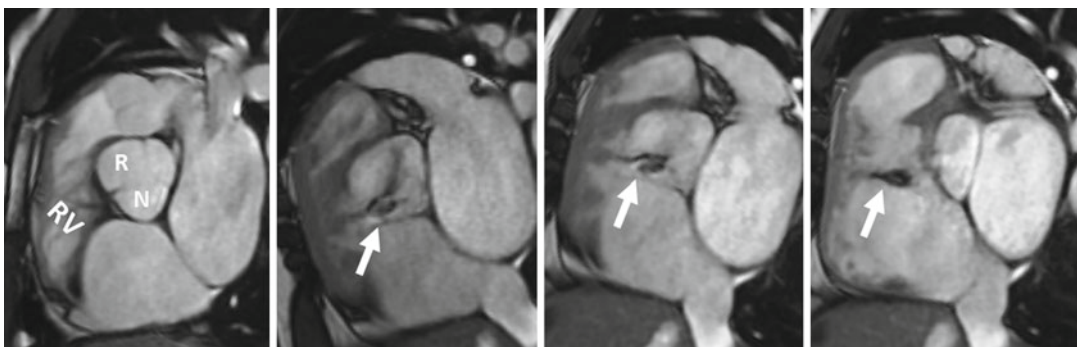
A 35-year-old male with a small membranous VSD. Short axis MR images show aortic regurgitation between the right (R) and noncoronary (N) sinuses
